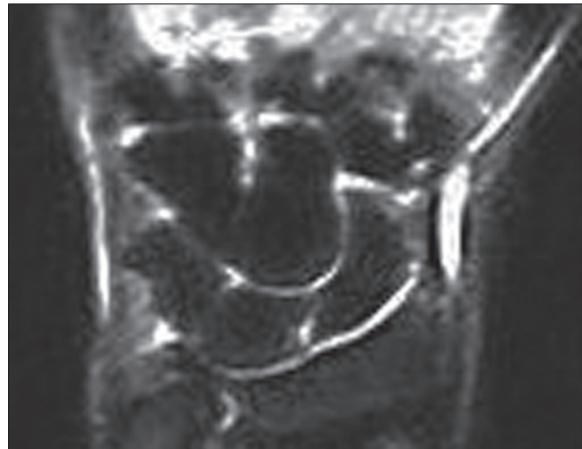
Coronal STIR magnetic resonance image demonstrates normal wrist.
